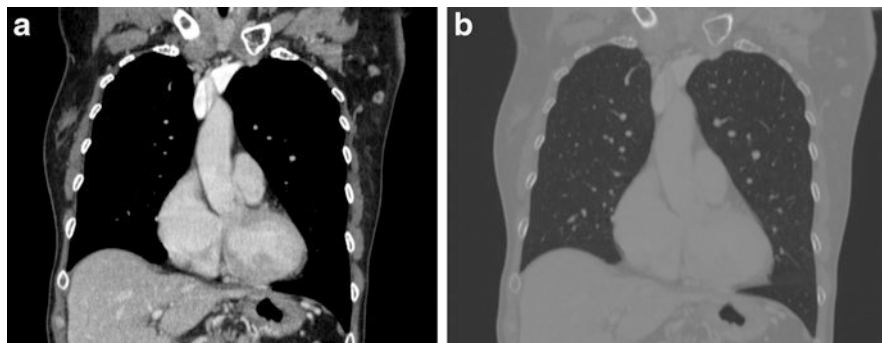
These pictures show the same coronal slice of a CT examination of the chest of one patient: they are reconstructed with the same kernel (smooth, B20). In (a) has been set a narrow window width with the centre at 20–40 HU in order to better evaluate tissues which differs between them having very low HU values; in (b) has been chosen a large window width with a high window centre at 550 HU in order to better evaluate bone and lung structures
